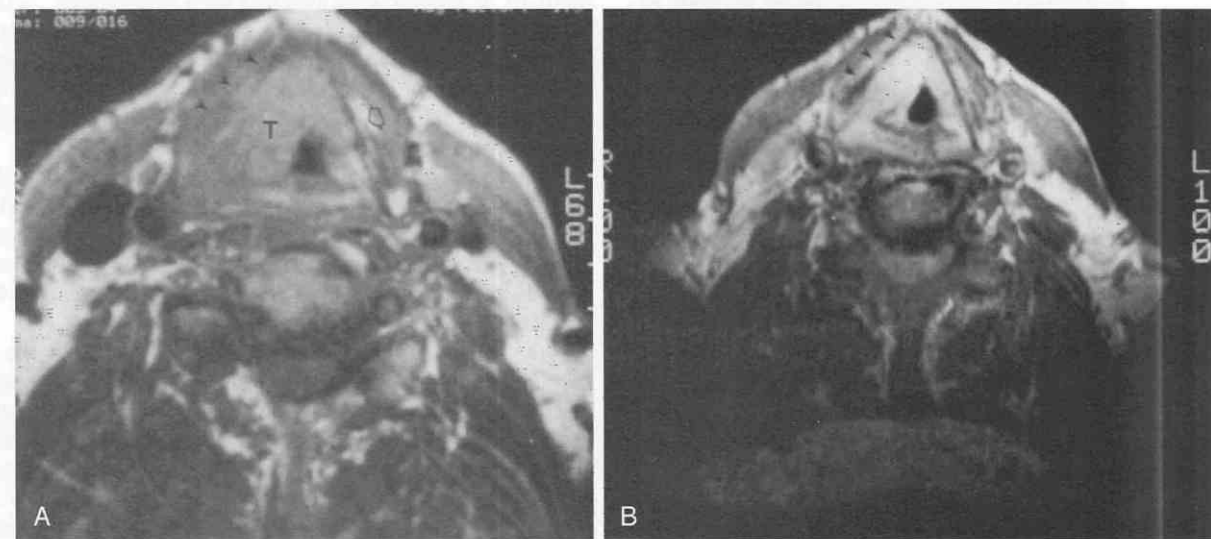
Tumor involving cartilage, axial MRI study. *A*, Short TR, short TE T1-weighted image shows tumor (T) against a suspicious area of cartilage (small arrowheads). The cartilage has a more intermediate signal rather than the high signal of fat. A normal thyroid lamina is seen on the opposite side (open arrow). *B*, Long TR, long TE T2-weighted image shows significant "brightening" compared with that in *A*. The behavior of this area is the same as that of the tumor. Nonossified cartilage remains as a dark linear structure within the higher-intensity tumor. (From Curtin HD: MR and CT of the larynx. In Thrall JH [ed]: Current Practice of Radiology, 3rd ed. St. Louis, Mosby-Year Book, 1994.)
